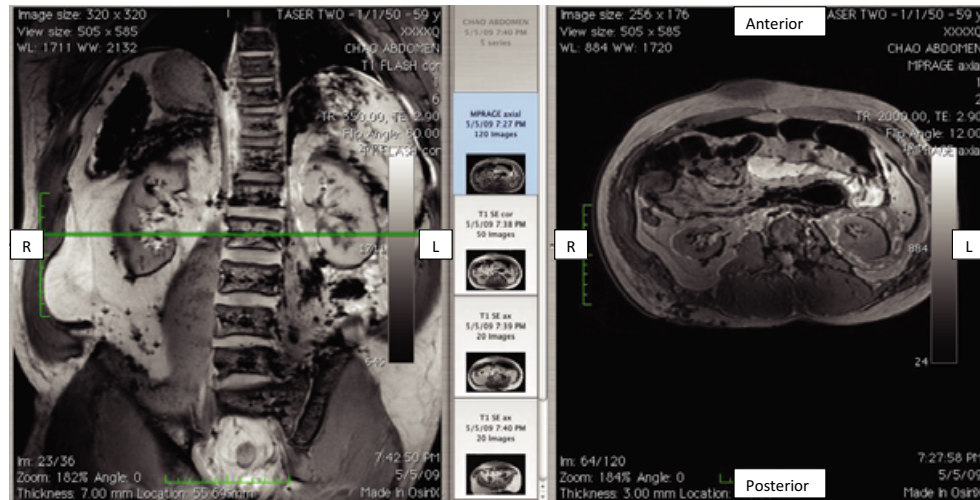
Representative posttest MR image of Torso 1 posterior impacts (shot 1L1). Left: coronal, right: axial.
